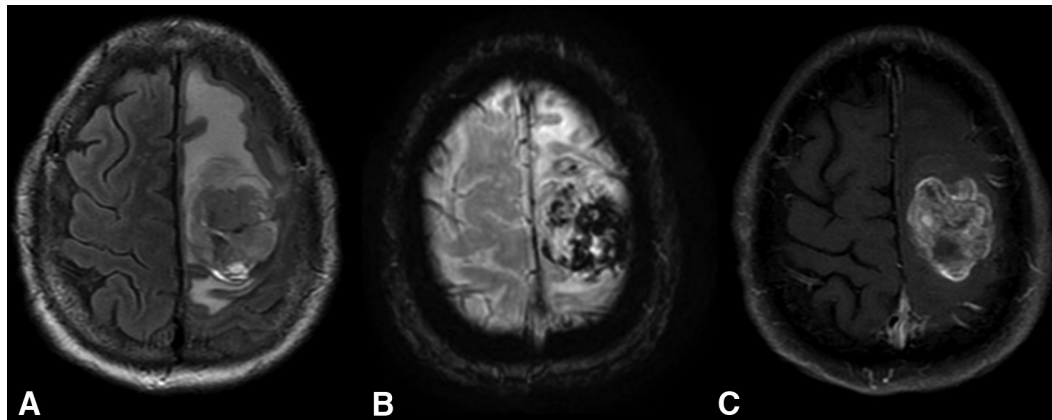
Extraventricular neurocytoma. Axial FLAIR (A), SWI (B), and postcontrast T1WI (C) show a heterogeneous lesion, presenting as hyperintensity on FLAIR (A) and intralesional hypointense areas on SWI (B), which may be due to hemorrhage, and heterogeneous enhancement (C). Vasogenic edema can be seen in the surrounding brain parenchyma.
